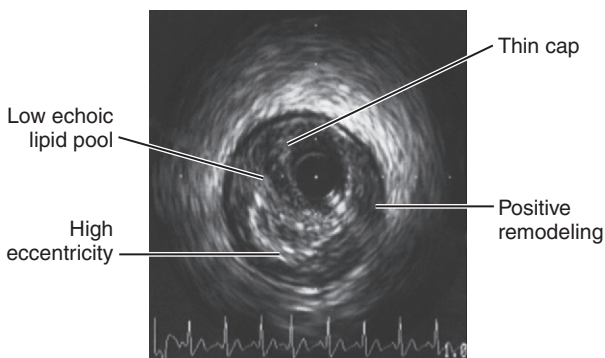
Intravascular ultrasound (IVUS) characteristics of vulnerable plaque.
